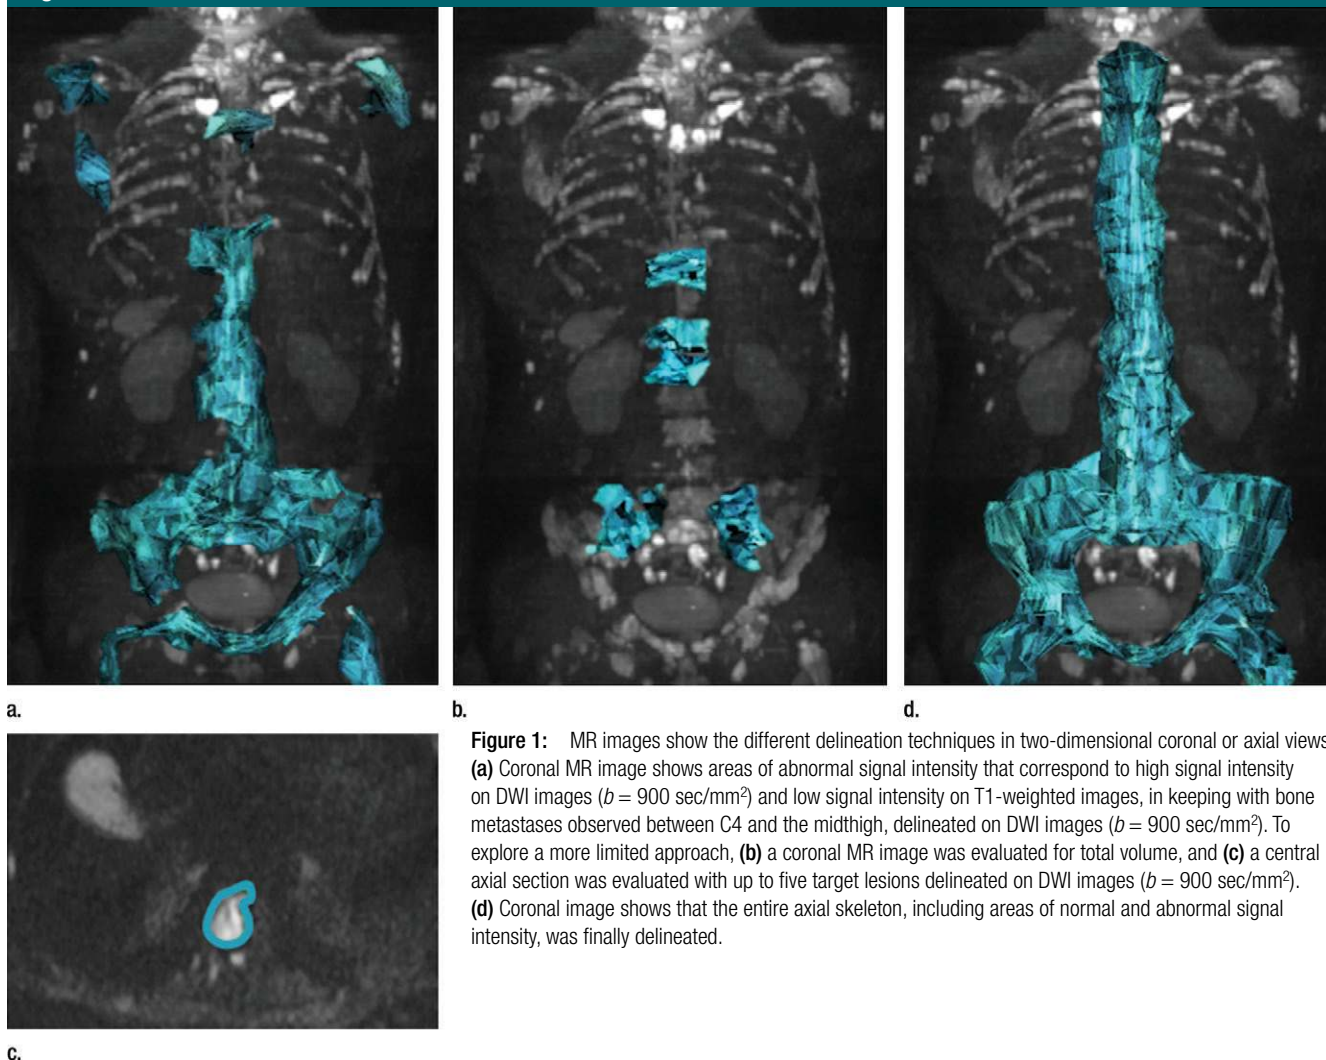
MR images show the different delineation techniques in two-dimensional coronal or axial views. (a) Coronal MR image shows areas of abnormal signal intensity that correspond to high signal intensity on DWI images ($b = 900 \text{ sec/mm}^2$) and low signal intensity on T1-weighted images, in keeping with bone metastases observed between C4 and the midthigh, delineated on DWI images ($b = 900 \text{ sec/mm}^2$). To explore a more limited approach, (b) a coronal MR image was evaluated for total volume, and (c) a central axial section was evaluated with up to five target lesions delineated on DWI images ($b = 900 \text{ sec/mm}^2$). (d) Coronal image shows that the entire axial skeleton, including areas of normal and abnormal signal intensity, was finally delineated.
